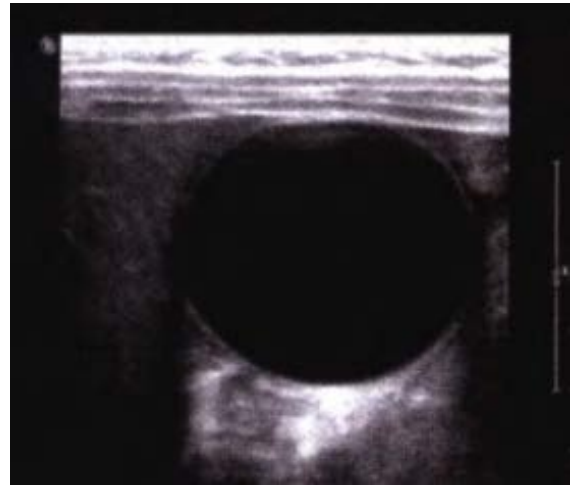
Color Doppler Ultrasound of abdomen, round cystic dark area represents SAPGB in small bowel
